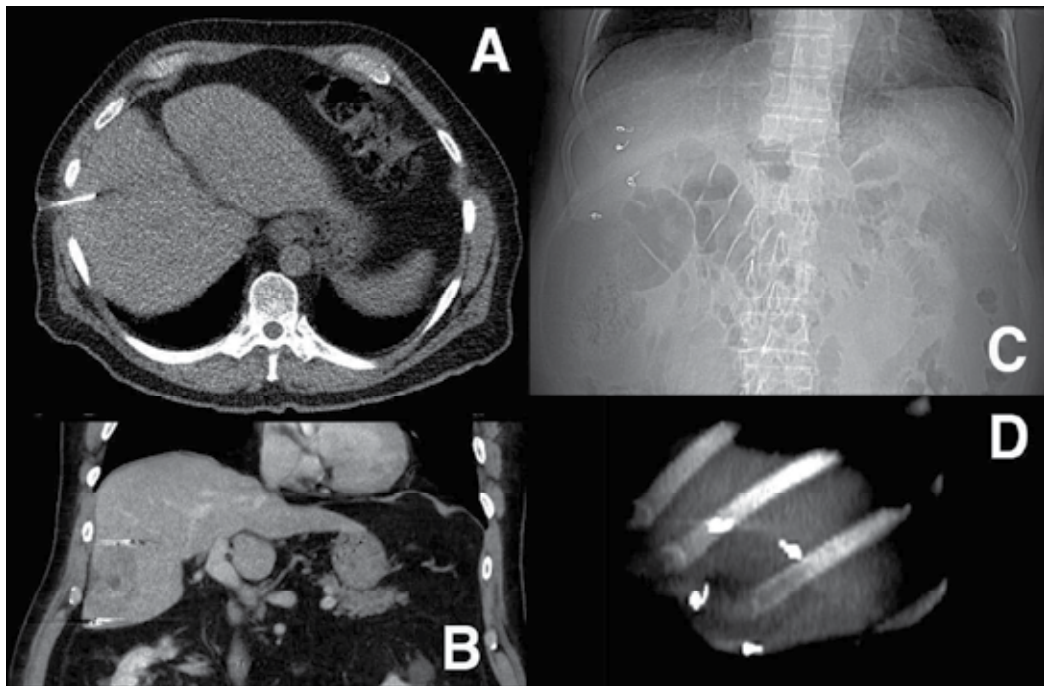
A) A 22G needle is placed with a low radiation dose CT scan to place a Nester platinum coil. This case has a 6 cm lesion and 4 coils were placed at different levels (B, C, D).
